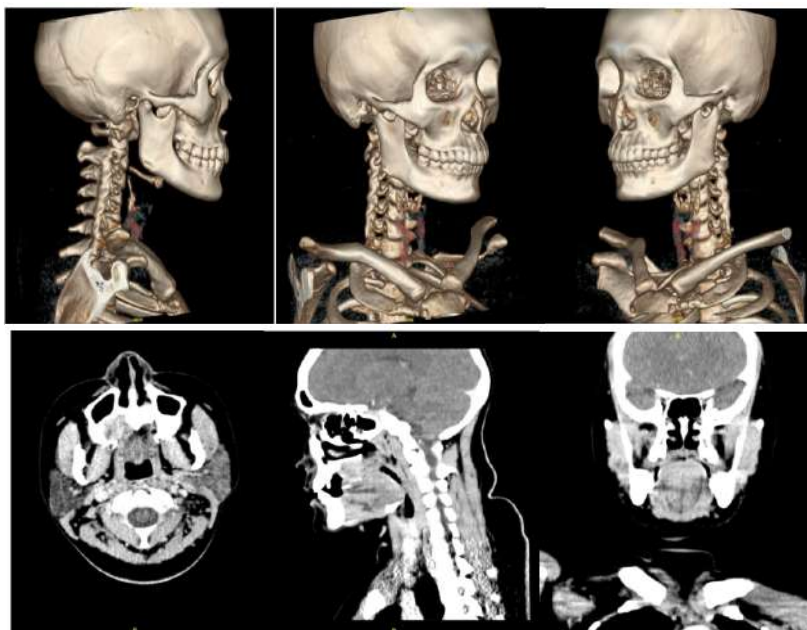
MST/CT scan examination
